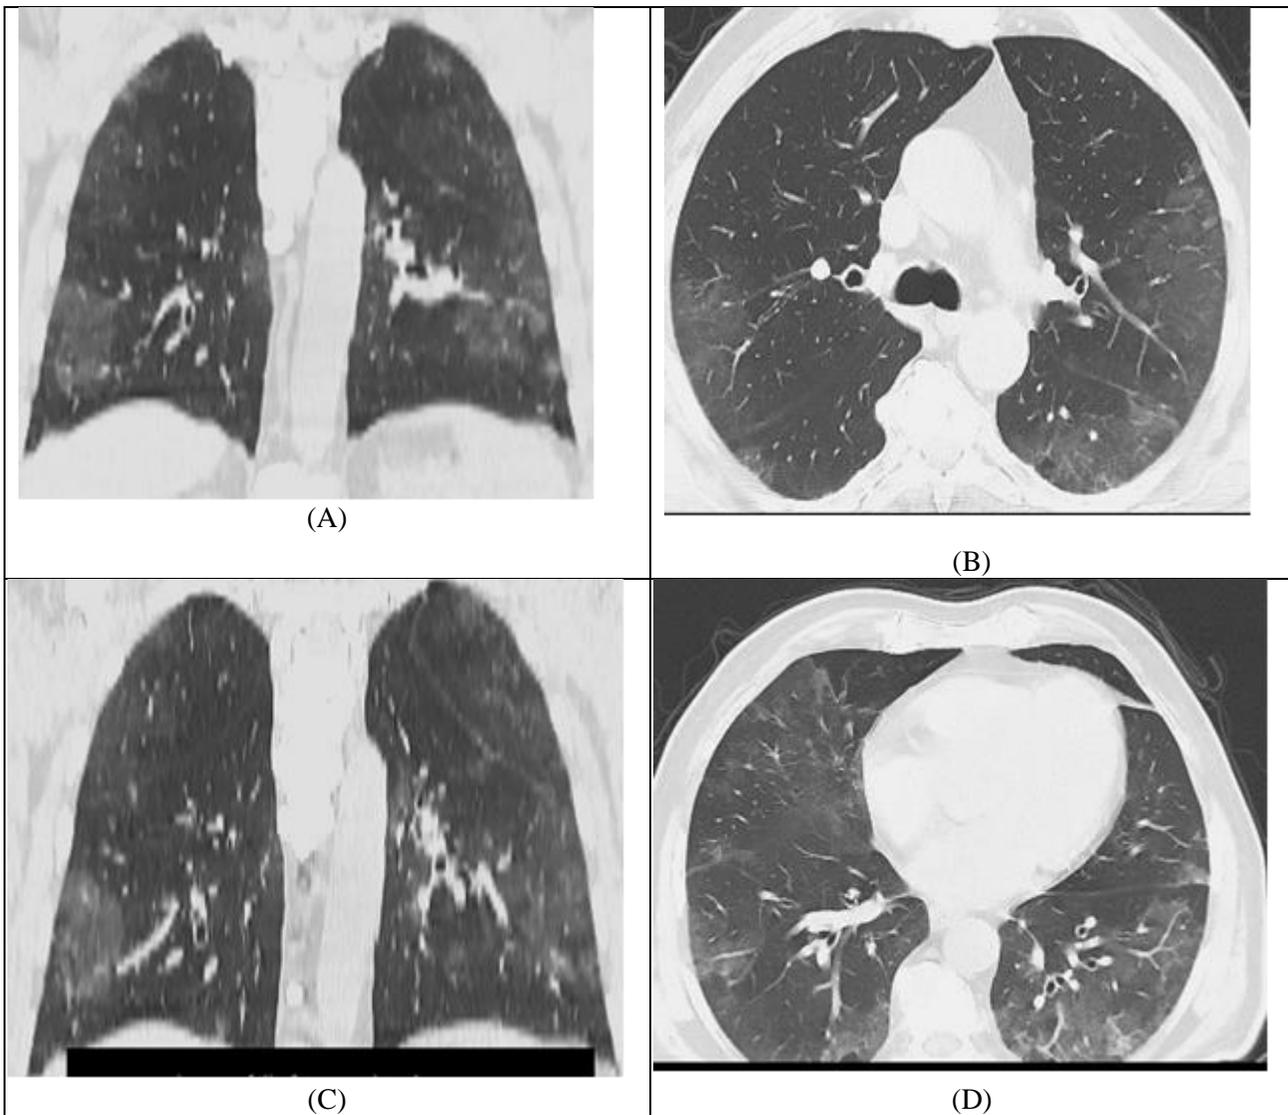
(A-D): CT coronal reformatted images (A, C) and axial (b) showing patchy ground glass opacifications, which are more peripherally and pleural based, CT axial image (D) is showing characteristic of crazy paving appearance intralobular lines within GGOs.
